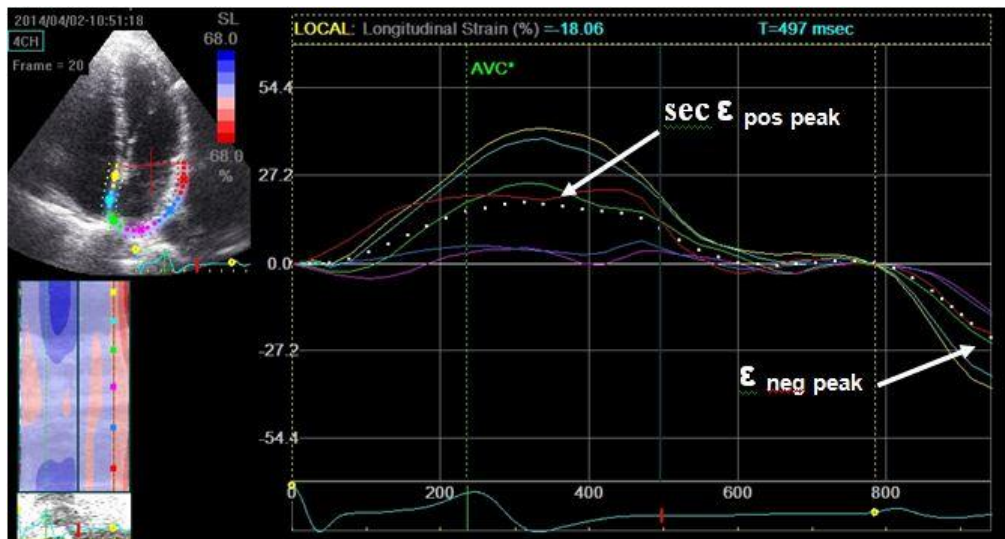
Measurement of second positive peak longitudinal LA strain (  $\text{sec } \epsilon_{\text{pos peak}}$  ) and negative peak longitudinal strain ( $\epsilon_{\text{neg peak}}$ ) from apical four chamber view ( the reference point is the onset of the p wave).
